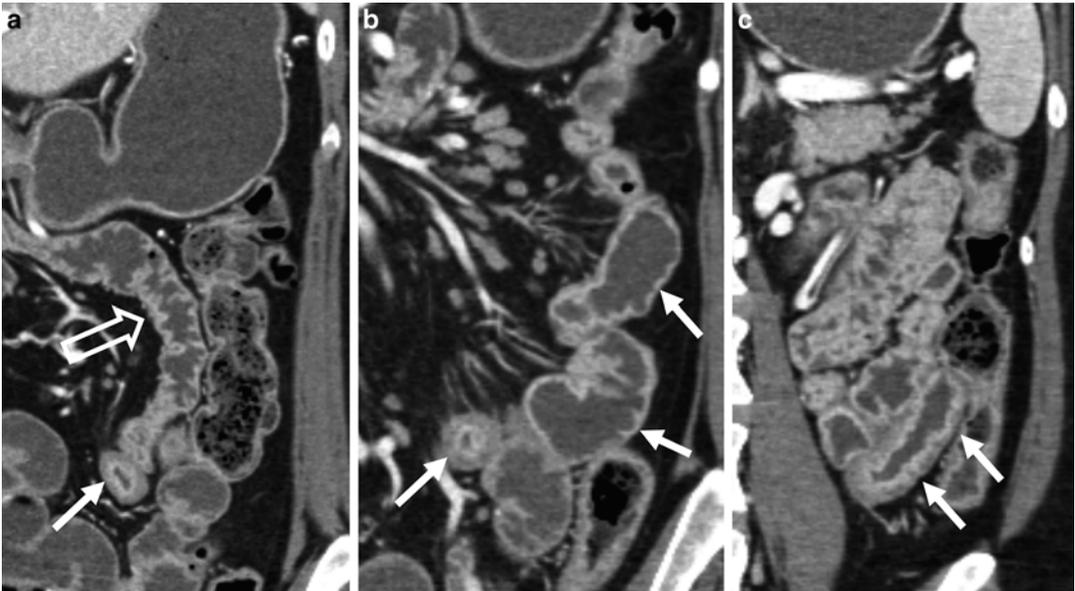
Typical appearance of Crohn's ileitis at CT enterography in patient with erythematous mucosa at ileoscopy. Note mural thickening and hyperenhancement of terminal ileum on axial and coronal images (a–c, arrows). In distal ileal loops, inflammation as demonstrated by hyperenhancement and wall thickening is more prominent
